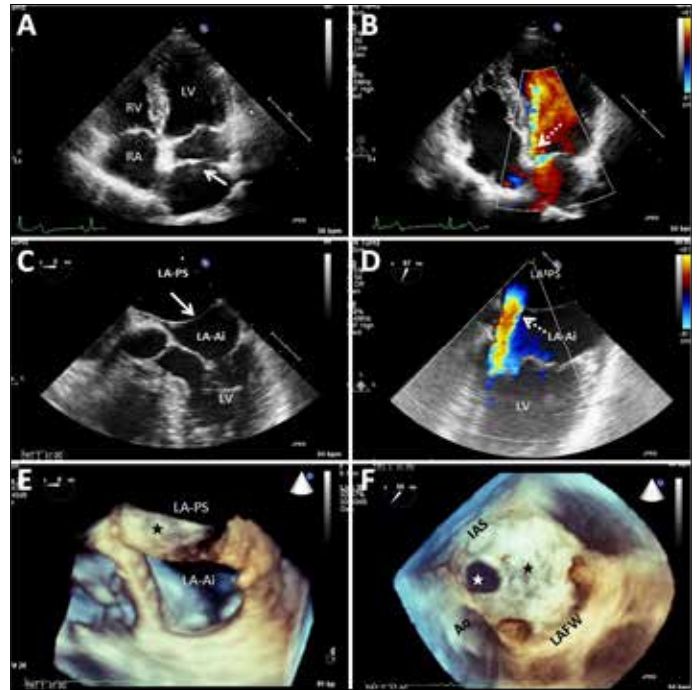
Two-dimensional TTE (A) and TEE (C) images show the membrane (arrows) dividing the left atrium into two chambers. 2D TTE (B) and TEE (D) Color Doppler studies revealed a single small fenestration (dotted arrows) on the membrane. 3D TEE image reconstruction (E and F) demonstrated the membrane (black stars) with a single, circular orifice/circular shaped defect (white star) located close to interatrial septum. The measured diameter was 13 mm, and the calculated area was 1.35 cm²
